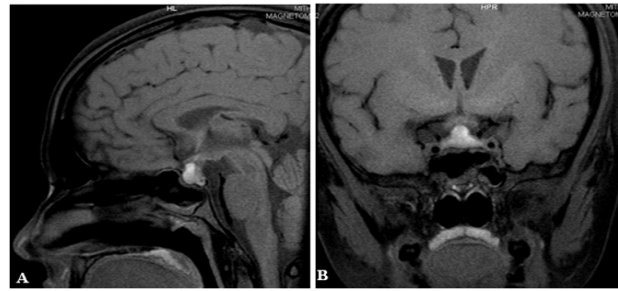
MRI brain-FLAIR sagittal (A) and coronal view (B) showing enlarged and hyperintense anterior pituitary suggestive of anterior pituitary infarct
